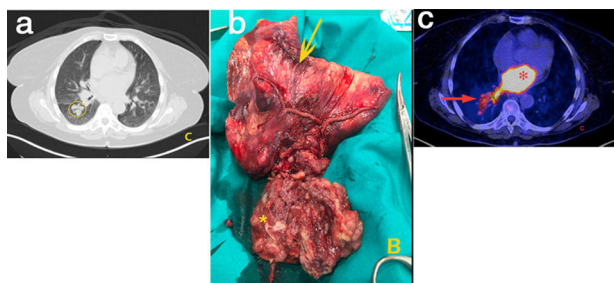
(A) PET/CT image showing a hypermetabolic mass extending from the pulmonary vein (arrow) to the left atrium (asterisk). (B) Right lower lobectomy (arrow) with intra-atrial mass (arrow). (C) CT scan showing multiple parenchymal metastases.
